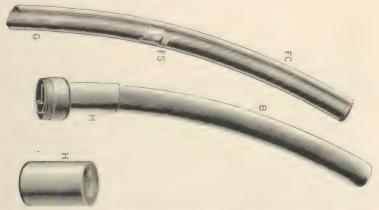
Instrument for radiographing a calculus in bladder.
